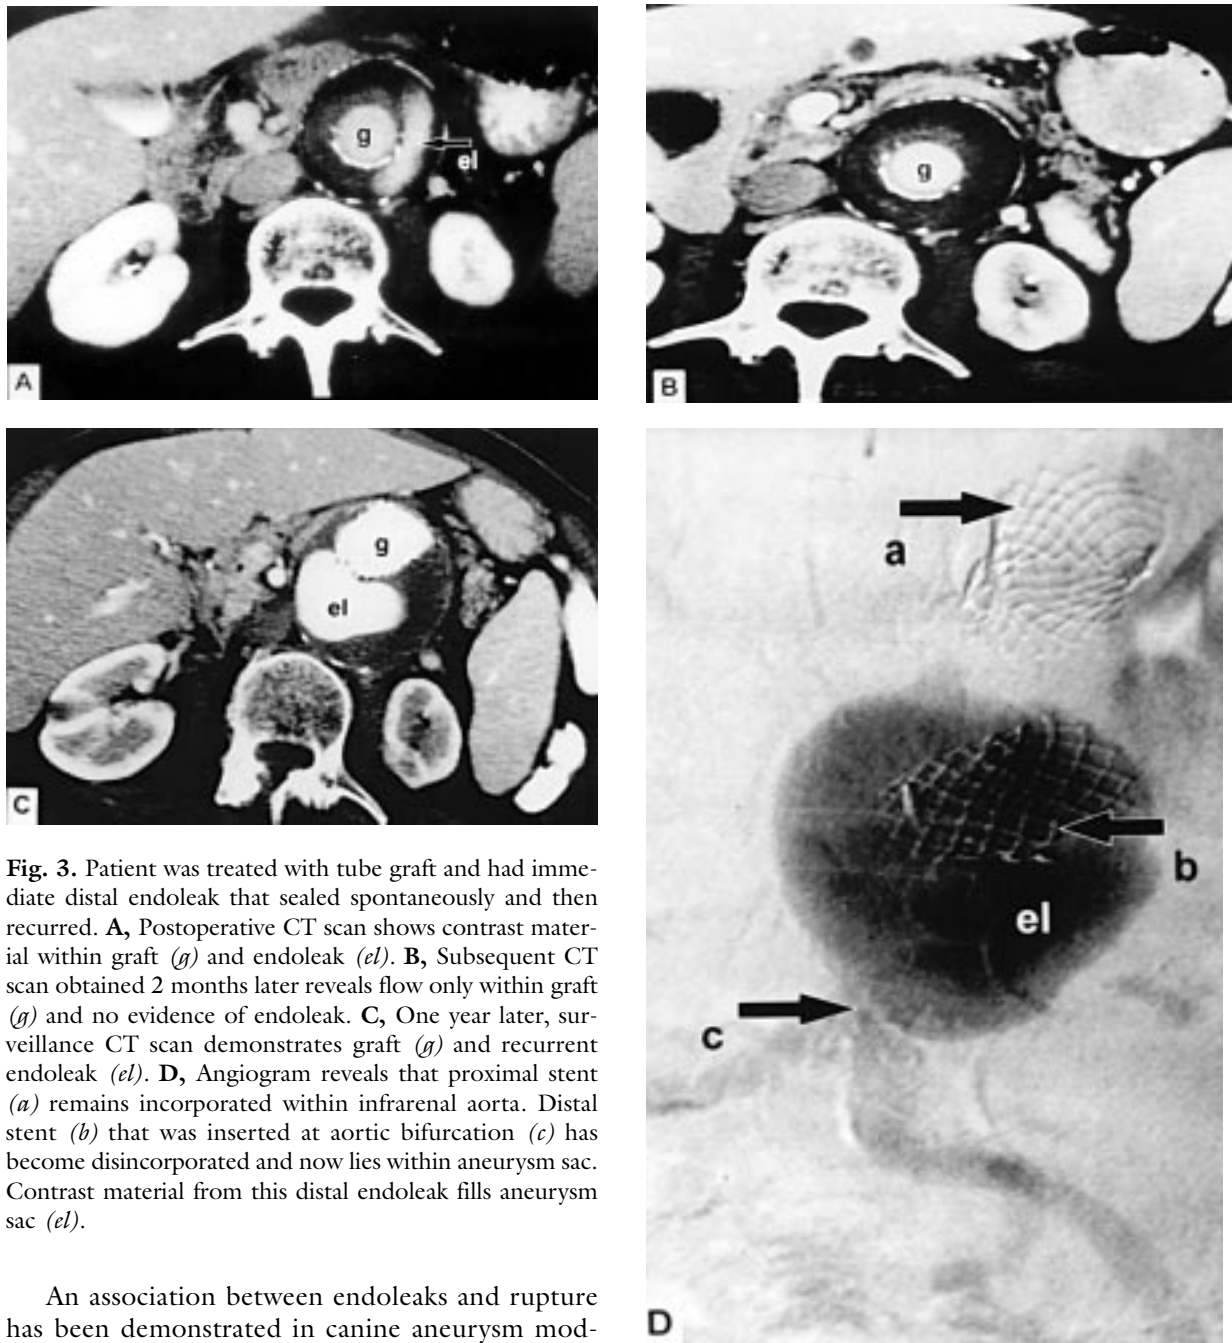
Patient was treated with tube graft and had immediate distal endoleak that sealed spontaneously and then recurred. A, Postoperative CT scan shows contrast material within graft (*g*) and endoleak (*el*). B, Subsequent CT scan obtained 2 months later reveals flow only within graft (*g*) and no evidence of endoleak. C, One year later, surveillance CT scan demonstrates graft (*g*) and recurrent endoleak (*el*). D, Angiogram reveals that proximal stent (*a*) remains incorporated within infrarenal aorta. Distal stent (*b*) that was inserted at aortic bifurcation (*c*) has become disincorporated and now lies within aneurysm sac. Contrast material from this distal endoleak fills aneurysm sac (*el*).
